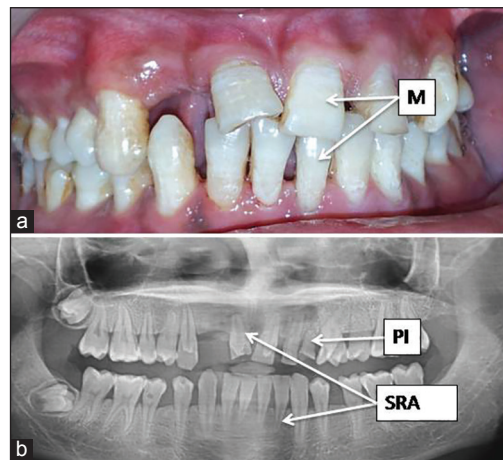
Intraoral photograph of maxillary and mandibular teeth (a) macrodontia (M) of all teeth. Panoramic radiograph (b) generalized short root anatomy, dense in denture with respect to 22, 24, 25, 34, 45 and congenitally missing 12, 28, 38 with impacted immature 18, 48
